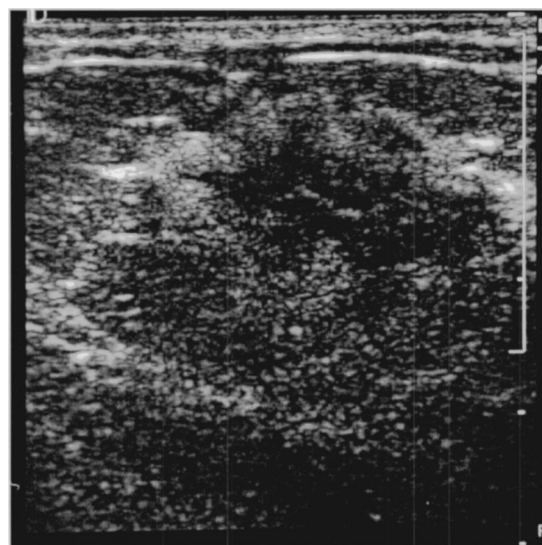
Ultrasound of a 54-year-old woman with an adenocarcinoma of the breast. Ultrasound shows a hypoechoic mass measuring 2.4 \times 2.5 \times 2.2 cm in the left lower inner quadrant.
